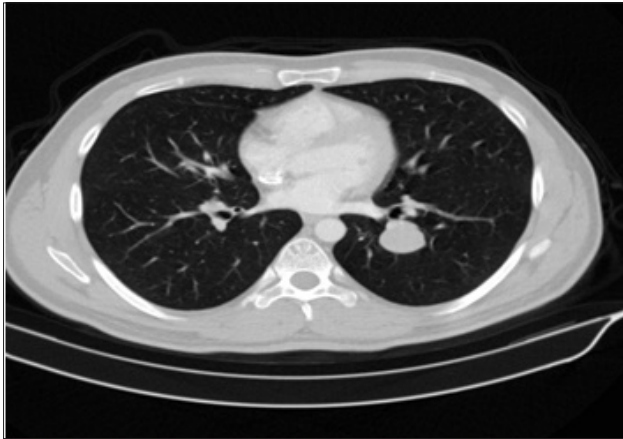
Case 1 - CT was performed on the left lower lobe with a smoothly defined, 26 mm sized nodule without calcification
